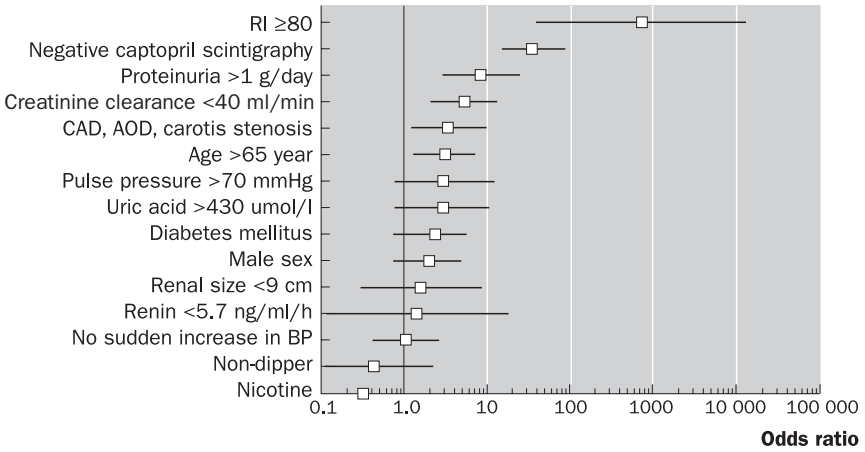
Unadjusted odds ratios for different factors regarding worsening of renal function. The squares give the odds ratio and the lines give the 95% confidence interval. RI, resistance index; CAD, coronary artery disease; AOD, arterial occlusive disease of the legs; CVD, cerebrovascular disease; non-dipper, no nocturnal decrease in blood pressure as determined from ambulatory 24-hour blood pressure measurements. § Odds ratio for a negative captopril scintigraphy which was calculated from published data [16,34].
